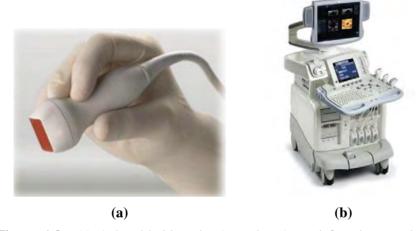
(a) A hand-held probe (transducer) used for ultrasound [18], (b) Ultrasound visualization system (source: *google*)
